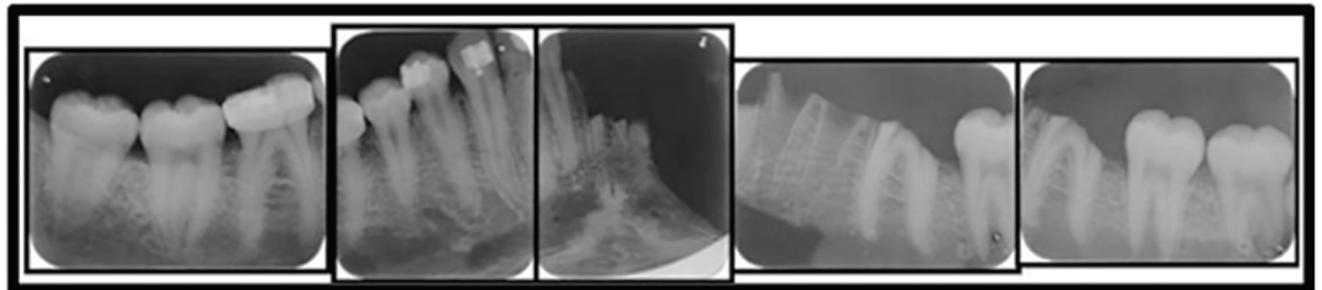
Postmortem periapical radiographs of the mandible
